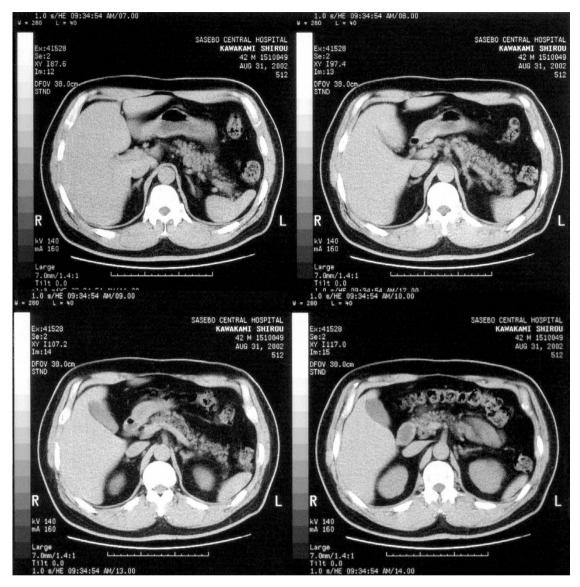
Abdominal CT scan showed almost normal adrenal glands with slight enlargement in the left gland.
